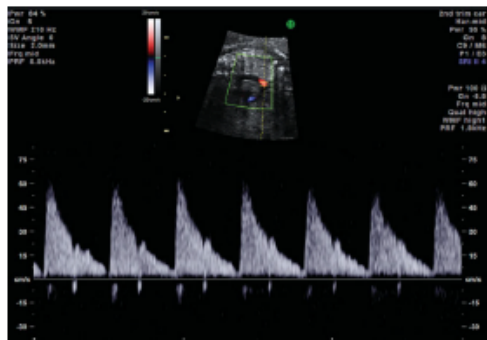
Doppler flow profile from the isthmus (sagittal view), showing continuous flow throughout systole and diastole.
